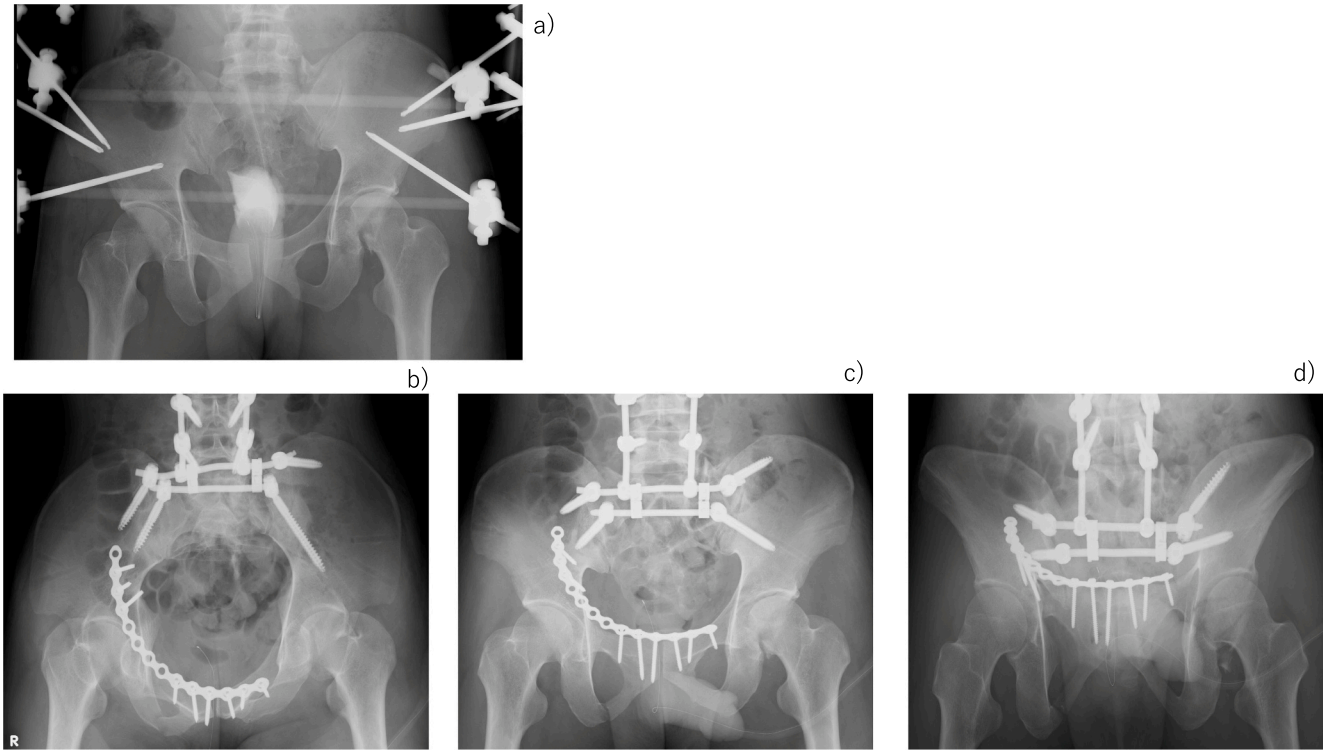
(a) Anteroposterior X-ray at the emergency room with a pelvic binder.
